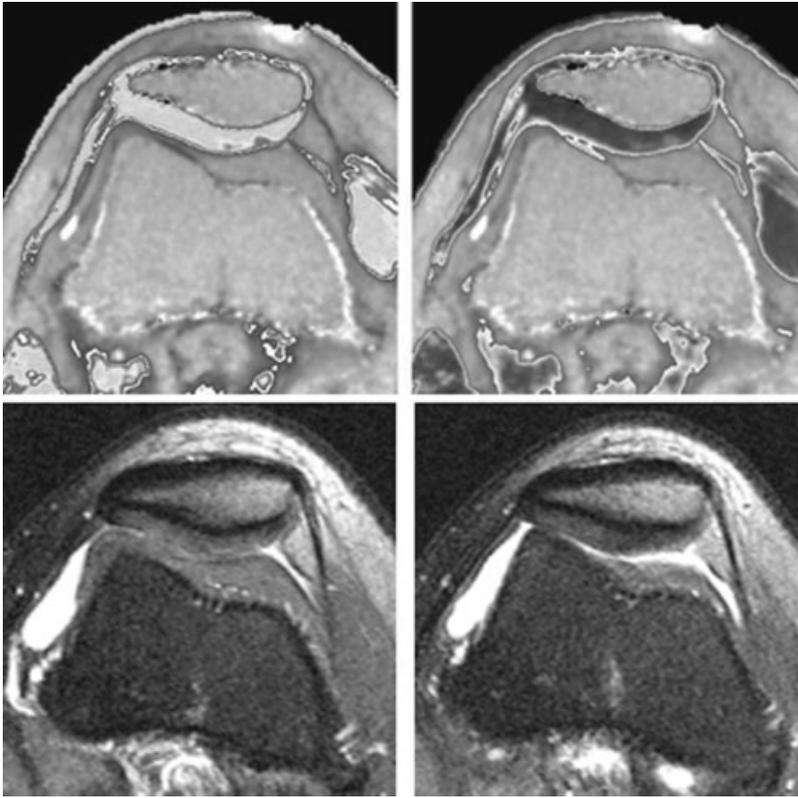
Superficial elevated T2 in 25-year-old male demonstrating focal superficial elevation in T2 of the medial facet of the patella. This finding is not apparent on the clinical MRI study obtained at 1.0 T (TR/TE: 3500 ms/45 ms). At arthroscopic surgery for ACL reconstruction, this site demonstrated focal cartilage fibrillation and superficial erosion (Beguín and Locker grade I/II).
